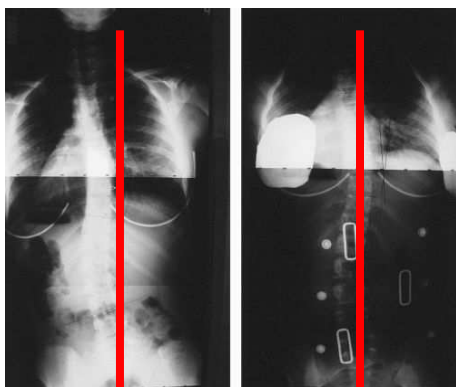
Out-of-orthosis and in-orthosis posterior-anterior radiographs. The vertical line was the central sacrum line. (Cite from Smith, 2004¹³)
